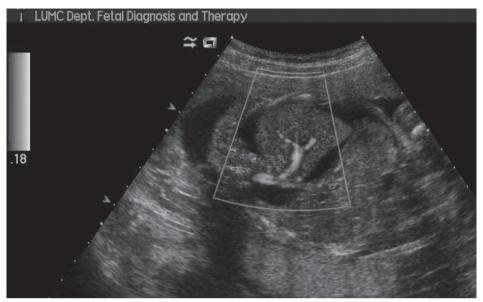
Color Doppler showing systemic artery, thus diagnosis of pulmonary sequestration
